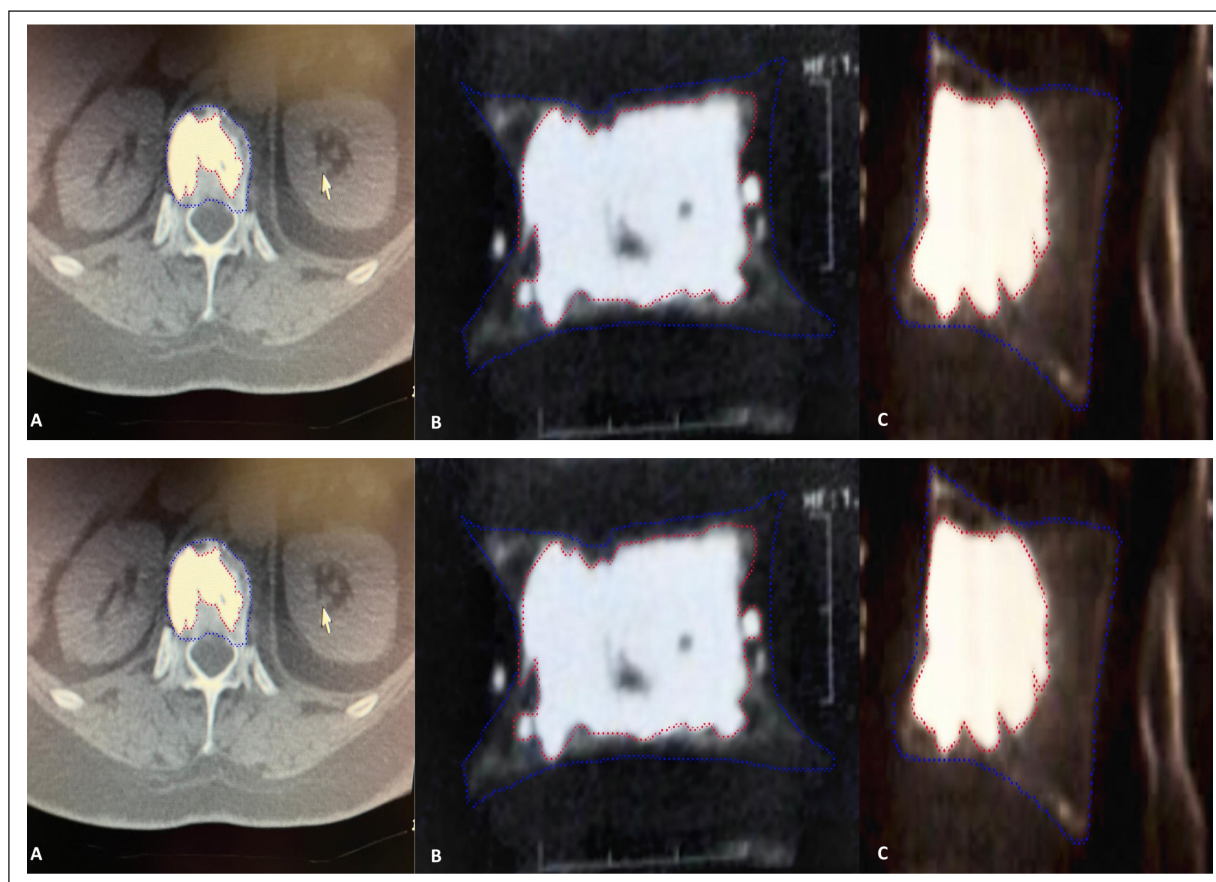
CT images of a patient. A, Axial cut. B, Coronal cut. C, Sagittal cut.
